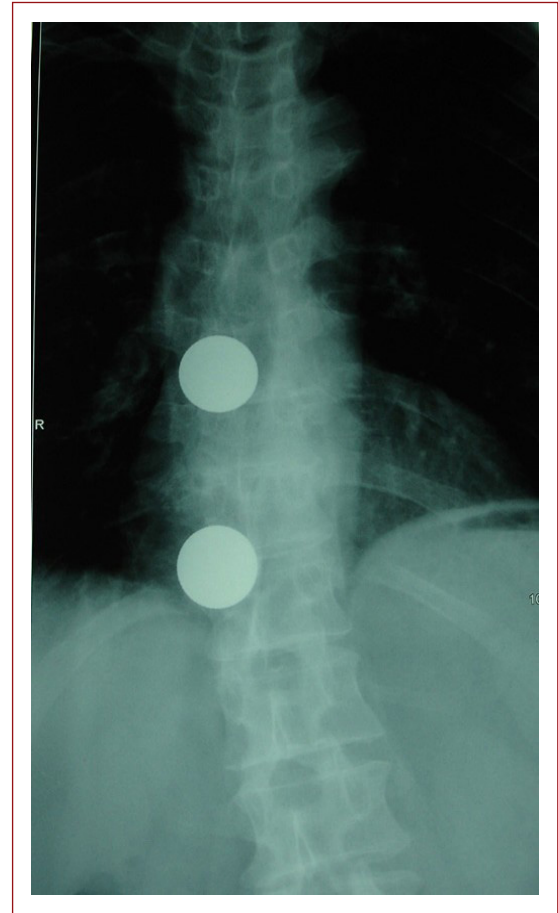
Preoperative radiographic level confirmation. Two radiolucent signs are always safer and more accurate.
